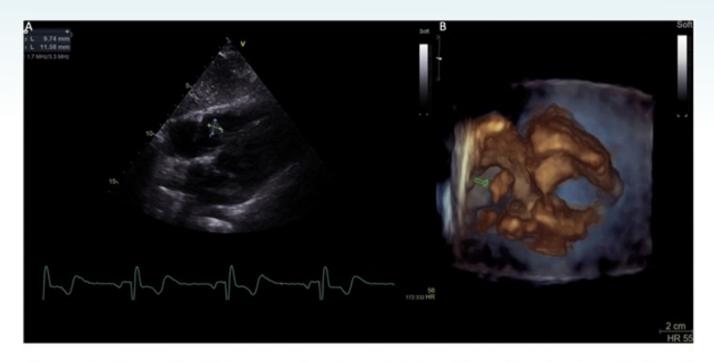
Transthoracic echocardiogram. A* – *Subcostal view showing a mobile round isoechogenic mass in the septal leaflet of the tricuspid valve. B* – *3D view of the aforementioned mass.*
